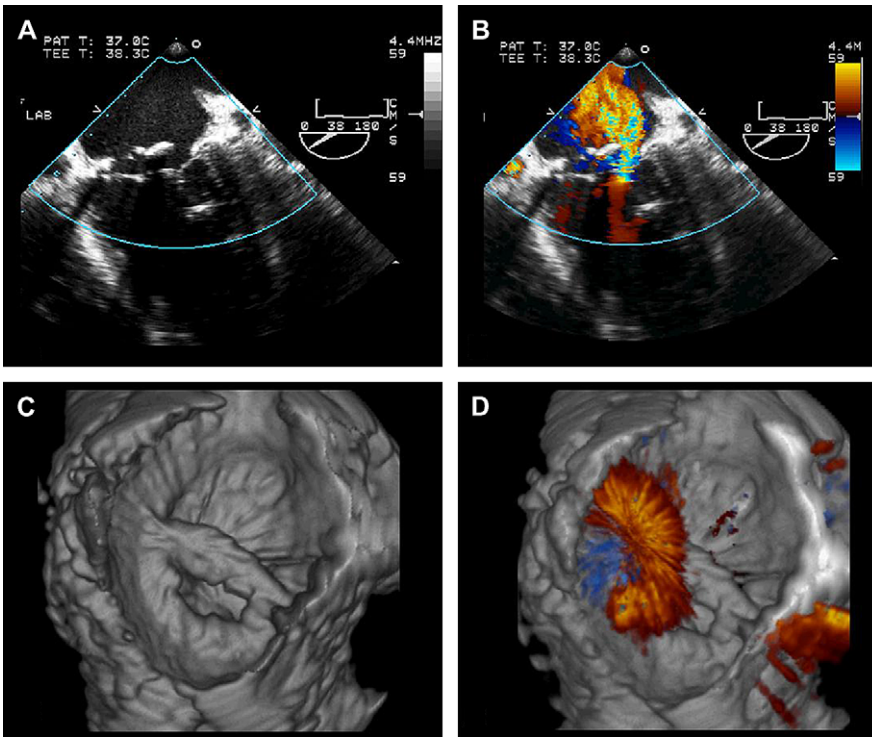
Patient with severe mitral regurgitation and presented with heart failure after mitral valve repair. On transesophageal echo (TEE) there is an echo density at the level of the mitral valve annulus (A), and on color flow Doppler (B) there is severe mitral regurgitation, so that it is difficult to differentiate whether there is valvular or para-ring regurgitation. Using a TEE rotational approach, a 3D reconstruction of the valve demonstrated dehiscence of the anterior portion of the mitral valve ring (C), severe mitral regurgitation that is valvular, and para-ring regurgitation (D). (Courtesy of L. Sugang, MD, and R. Lang, MD, Chicago, IL.)
